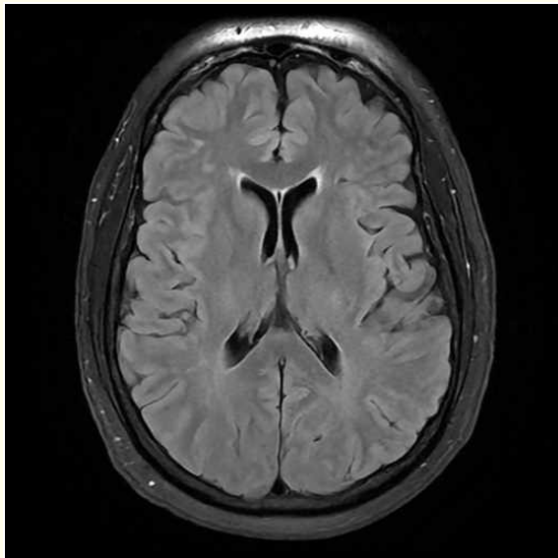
Axial plane FLAIR MRI of white matter hyperintensities around the ventricles.
